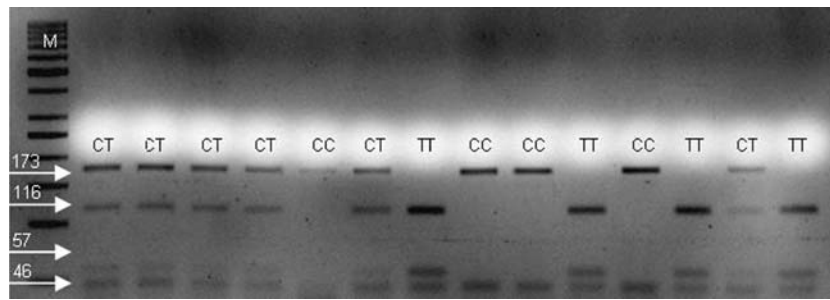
Genotype analysis at -77 promoter polymorphic site of *XRCC1* by digestion of PCR product with BsrB I restriction endonuclease. Band patterns of heterozygote with CT, homozygote with CC and TT.
